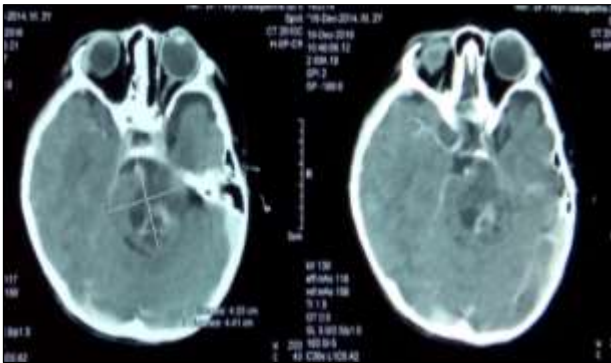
Head CT scan with contrast administration suggesting a solid mass in the pontine.
